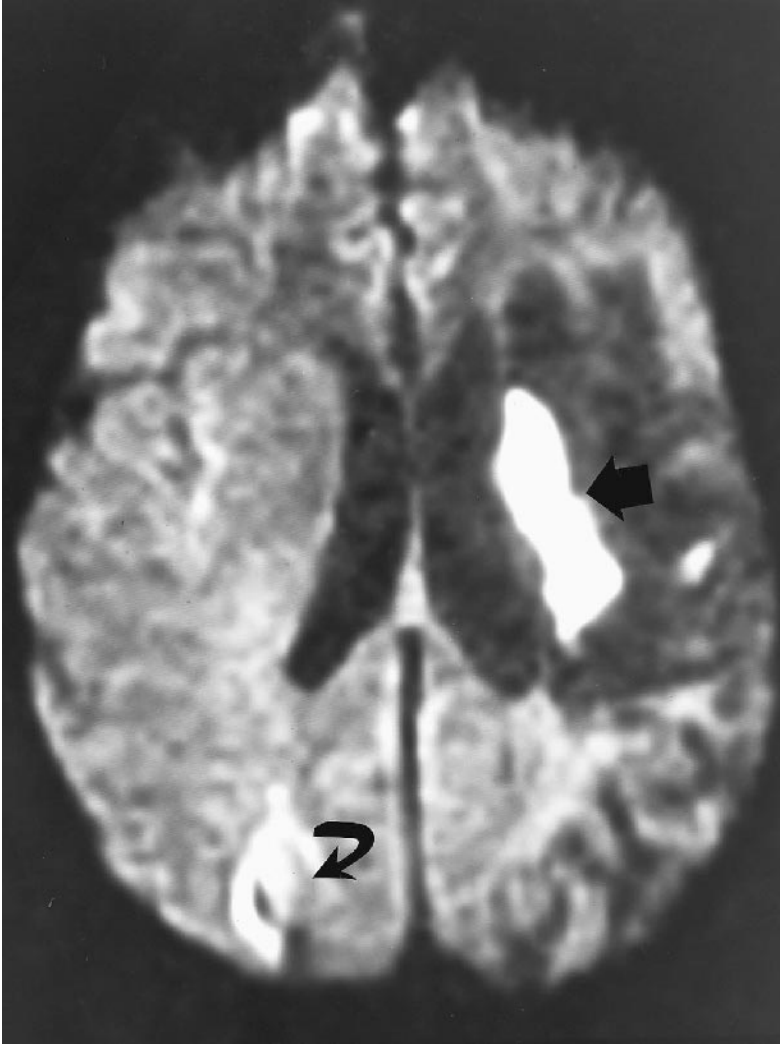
Diffusion weighted MRI. A diffusion weighted MRI sequence demonstrates an acute infarct in the region of a previous middle cerebral artery territory infarction (dark arrow) as well as an acute watershed type infarct in the right parietal region (curved arrow).
